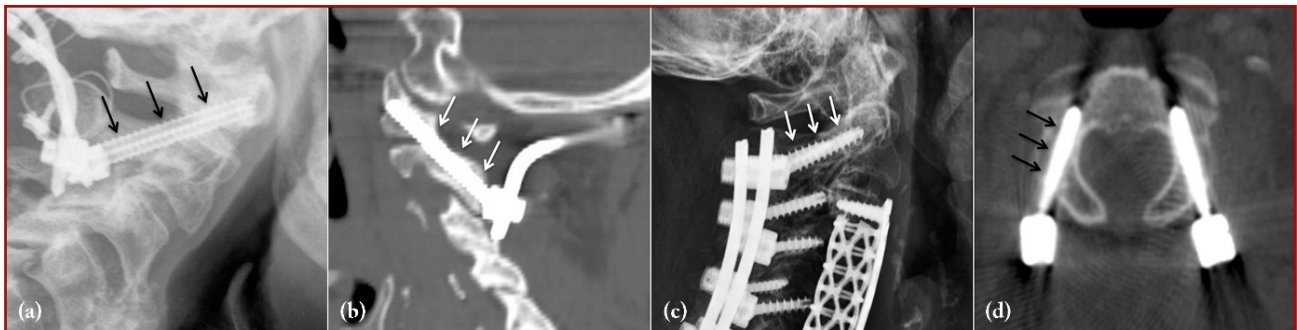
X-ray and CT demonstrations of the paths of the C1-C2 transarticular screw and C2 pedicle screw on two different patients. Postoperative lateral plain radiograph (a) and sagittal CT (b) images of a patient with unstable dens fracture. C1-C2 transarticular screw traverses the isthmus of the C2 pars-interarticularis, passing the atlantoaxial joint and reaching the lateral mass of C1 (black and white arrows). Postoperative lateral plain radiograph (c) and axial CT (d) images of a patient with cervical spinal stenosis. C2 pedicle screw passes the C2 isthmus and pedicle and reaches the C2 vertebral body (white and black arrows)
